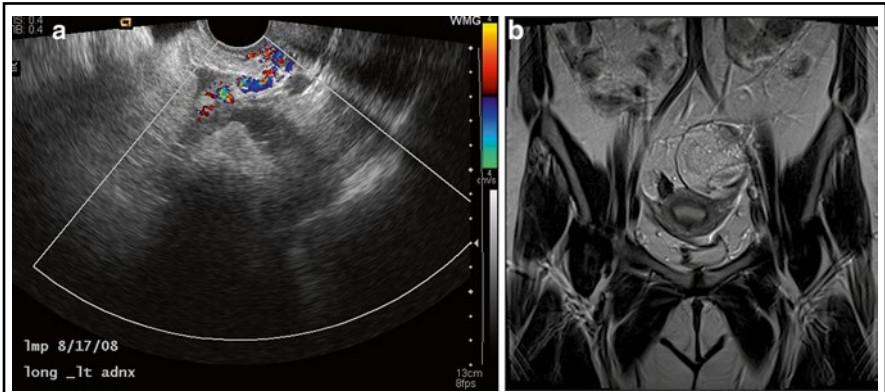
OVARIAN DERMOID. “Tip of the iceberg” configuration of an ovarian dermoid (cystic teratoma) is noted on ultrasound (a); the multiple types of tissue that make up a dermoid such as hair, blood, fat, cartilage, and calcifications create an acoustic shadow, which blocks all sound waves and the mass is essentially obscured. The corresponding MRI (b) shows the extent and complex nature of the mass. Fat identified in an ovarian mass on CT or MRI is classic for dermoid
